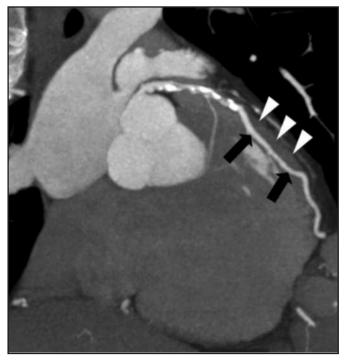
An MIP sagittal-oblique view of a CTA showing myocardial bridging referring to the middle segment of the LAD (arrows) and embedding in the myocardium (arrowheads).
